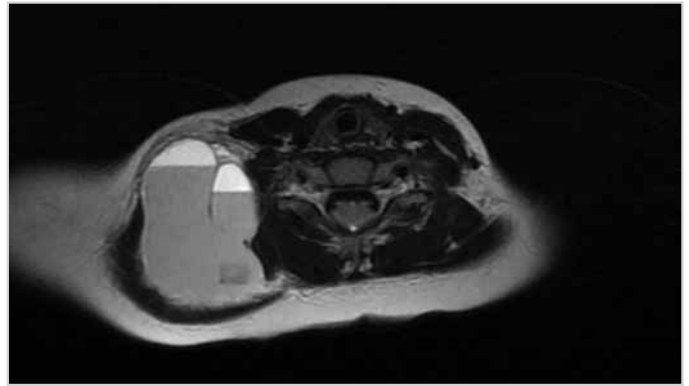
MRI scan showing 63×52×40 mm, well-circumscribed, septated, cystic mass in the lateral border of sternocleidomastoid muscle superior to clavicle and anterior to supraspinatus muscle
